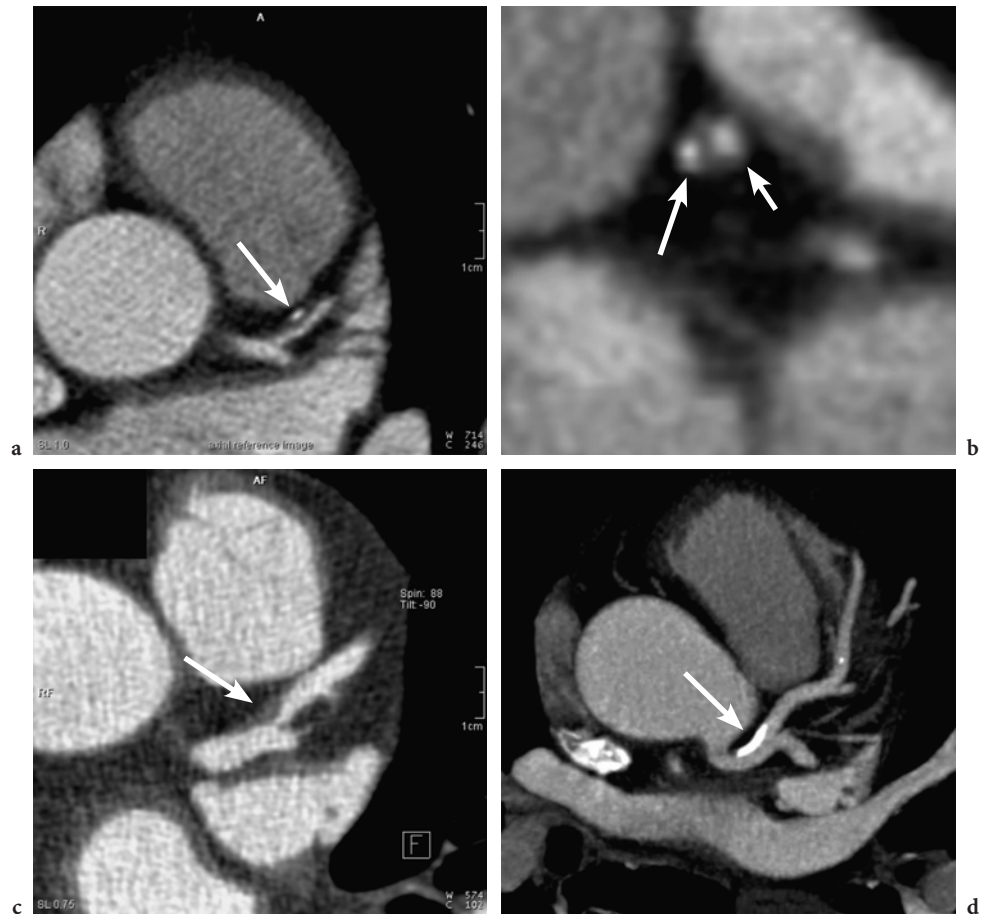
Coronary atherosclerotic plaque visualization with 16-slice CT. a A partly calcified plaque in the proximal LAD is depicted on an axial cross-sectional image with 1-mm slice thickness. b The cross-section of the LAD lesion shows the partly calcified plaque (*large arrow* calcified plaque, *small arrow* contrast-enhanced coronary artery lumen). c Non-calcified plaque (*arrow*) at the proximal LAD visualized with MPR. d Completely calcified plaque (*arrow*) in the LM in MIP
